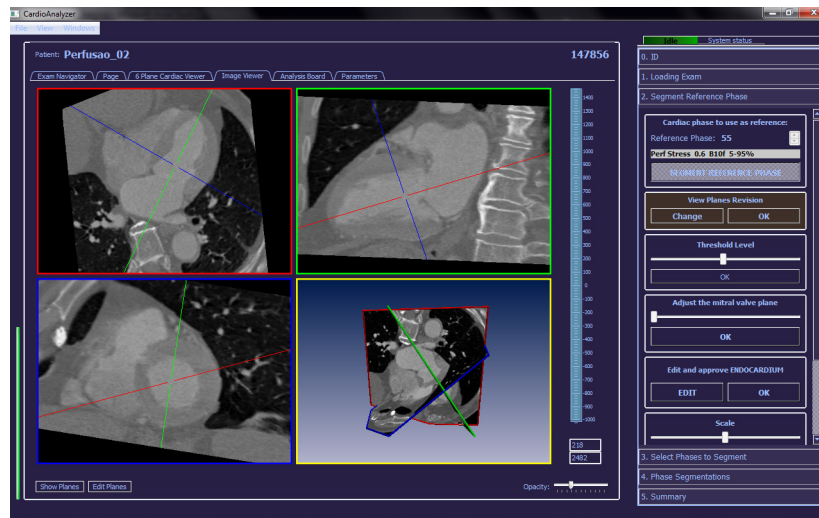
General view of CardioAnalyzer showing different views of a CTA exam and interface widgets for LV segmentation support.
